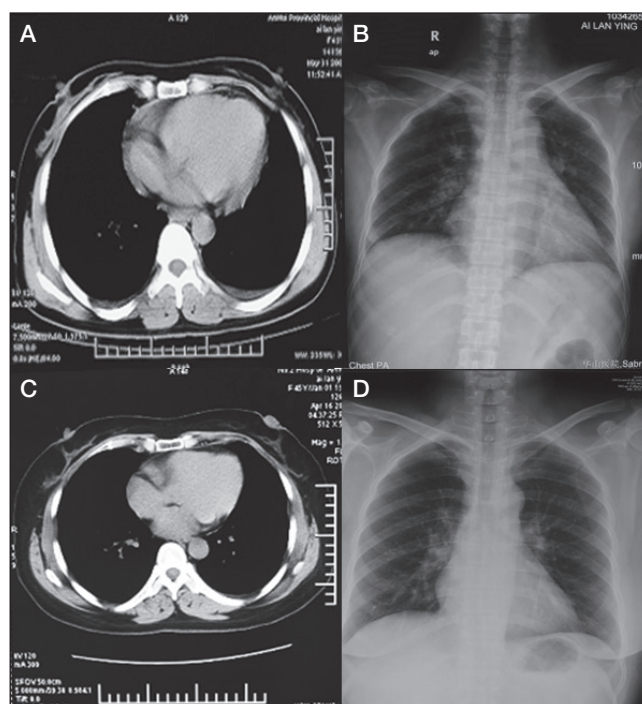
Cardiomegaly, pleural effusion and pericardial effusion as shown in chest radiography before (A,B) and after (C,D) thalidomide therapy
